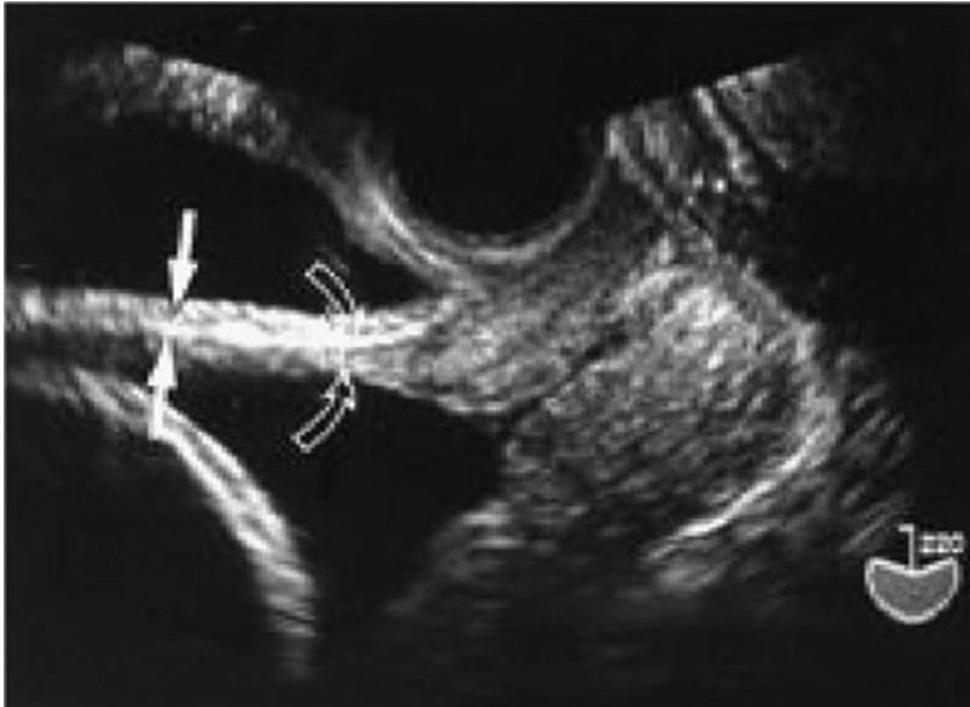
LUS and bladder full. Open arrow indicated the uterine wall and solid arrow indicated the bladder wall, LUS, lower uterine segment; TVS, and transvaginal ultrasound.
